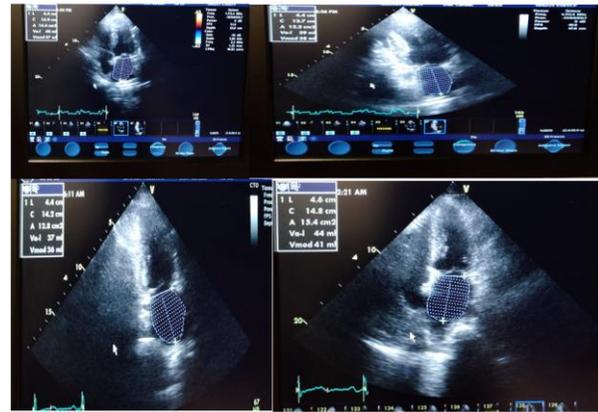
Echocardiography showing increased Left Atrial Volume (LAV) in uncontrolled hypertension patients
